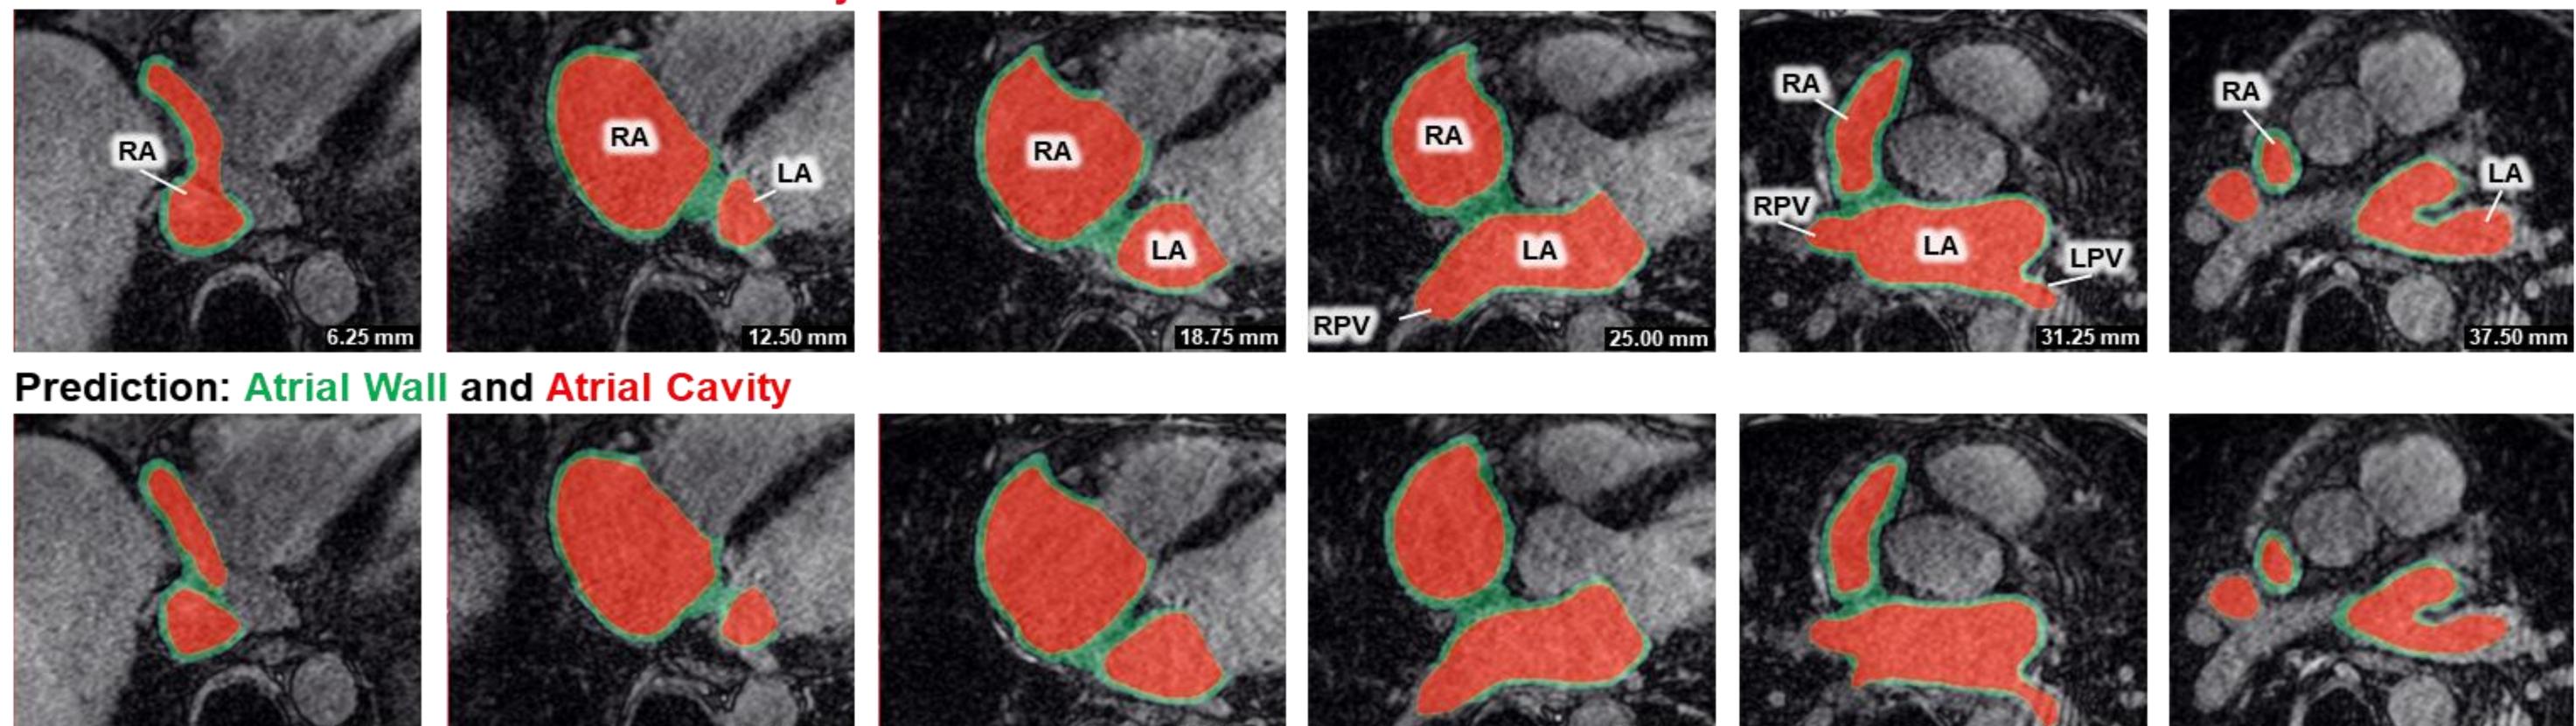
Side-by-side comparisons between manual (1st row) and automated (2nd row) segmentations in typical 2D late gadolinium-enhanced (LGE)-MRI slices. The depth of the LGE-MRI for each slice is shown in mm. The bi-atrial wall is shown in green, while the cavity is shown in red. RA, right atrium; LA, left atrium; RPV, right pulmonary vein; LPV, left pulmonary vein.
